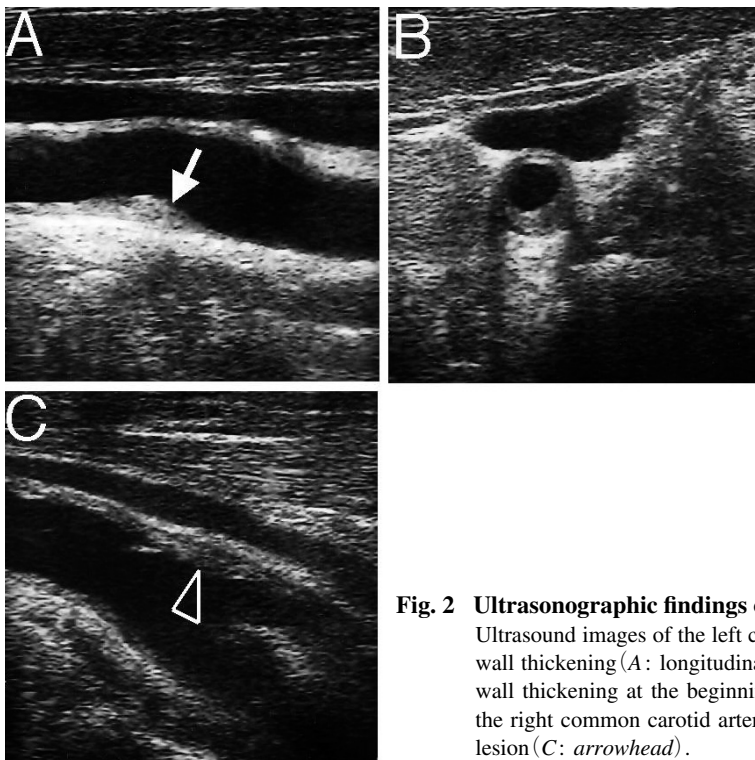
Ultrasonographic findings of the common carotid arteries
